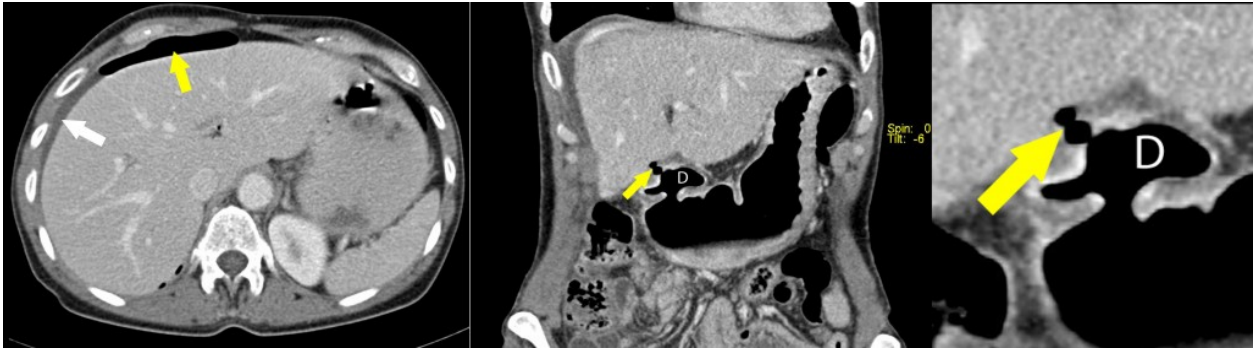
Abdominal CT scan. *Perforated duodenal ulcer. Transverse CT image on the left shows the free gas anterior to the liver (yellow arrow), as well some free fluid (white arrow). On the coronal image (middle and, magnified, right): defect (arrow) in the wall of the duodenum (D), due to a perforated peptic ulcer.*
